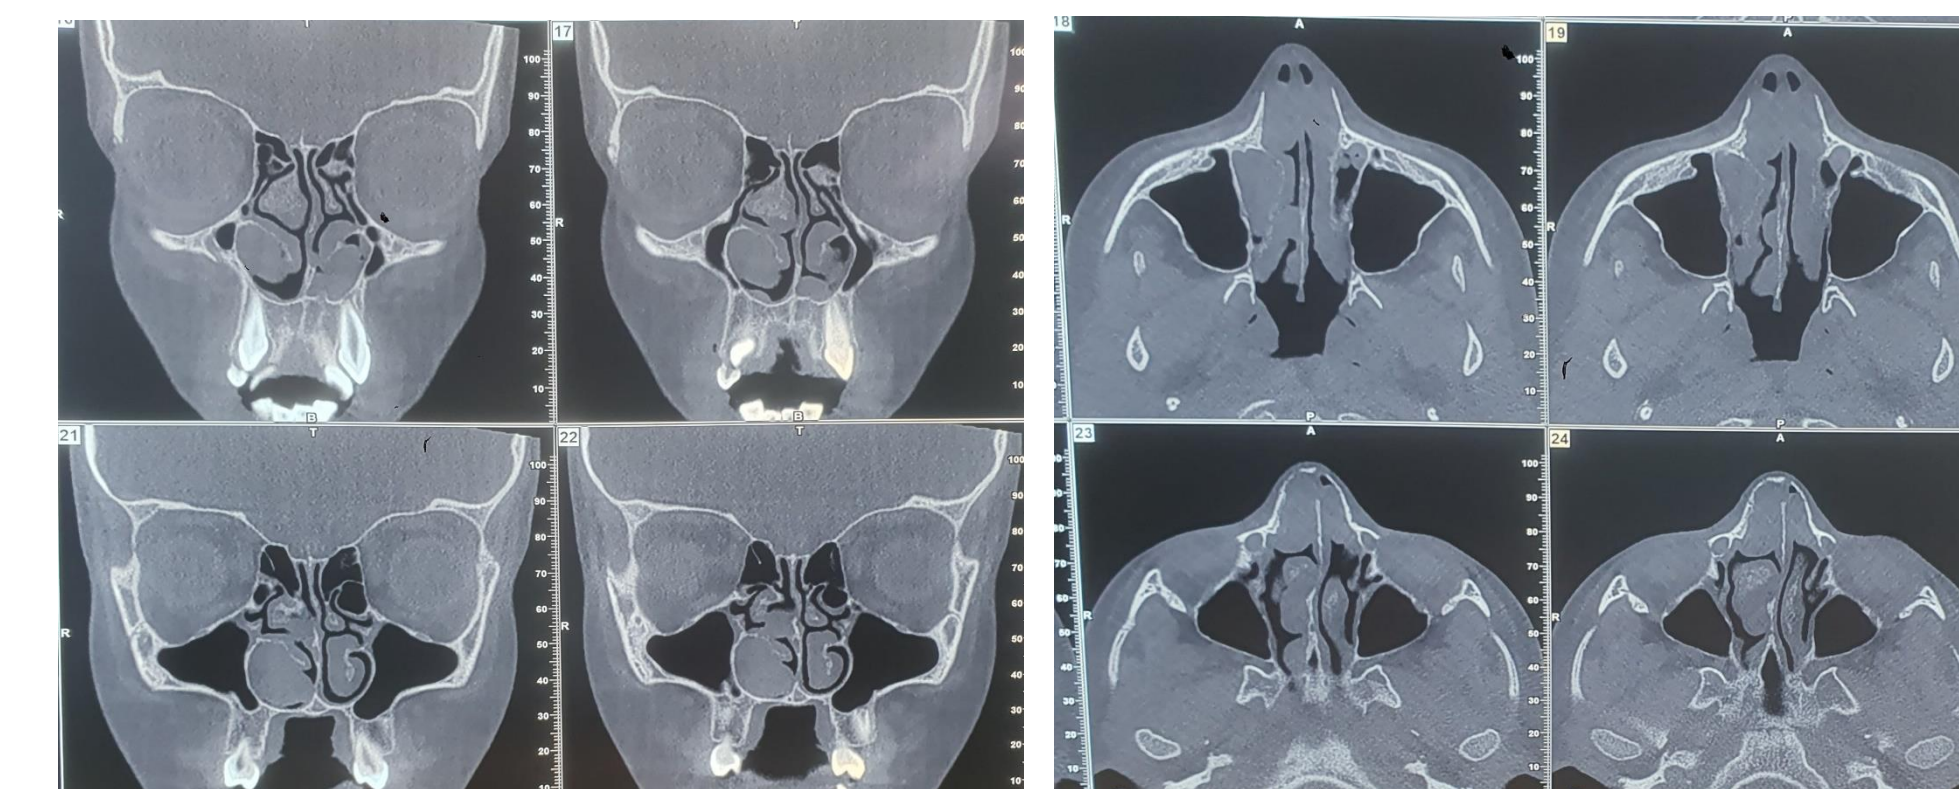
CT scan findings
